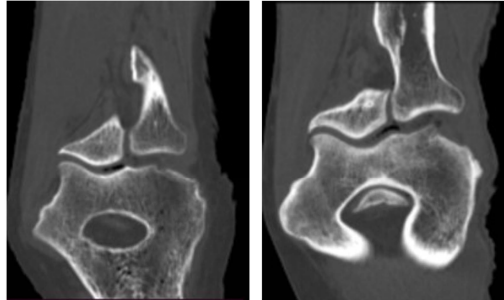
Positive Intra-Articular Free Air on Elbow CT
